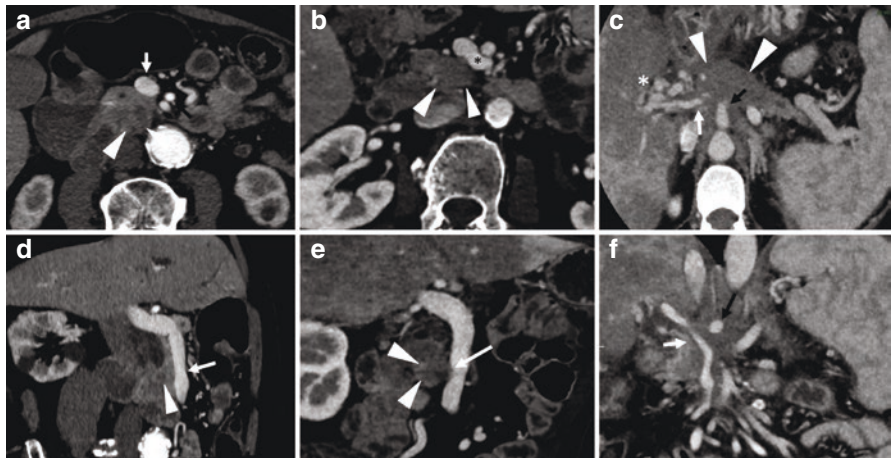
Example of CT images showing venous invasion by the tumor. CT with contrast injection at the pancreatic arterial phase, axial (b) and coronal (a, c, and d) views showing several lesions in the pancreatic head (white arrowheads) with different types of venous involvement (black arrowheads): (a) contact $<180^\circ$ with the superior mesenteric vein, with no stenosis, (b) contact $<180^\circ$ with the superior mesenteric vein, with stenosis, (c) contact $<180^\circ$ with the superior mesenteric vein, with a teardrop sign (e), (f) encasement of the superior mesenteric vein $>180^\circ$, with stenosis
